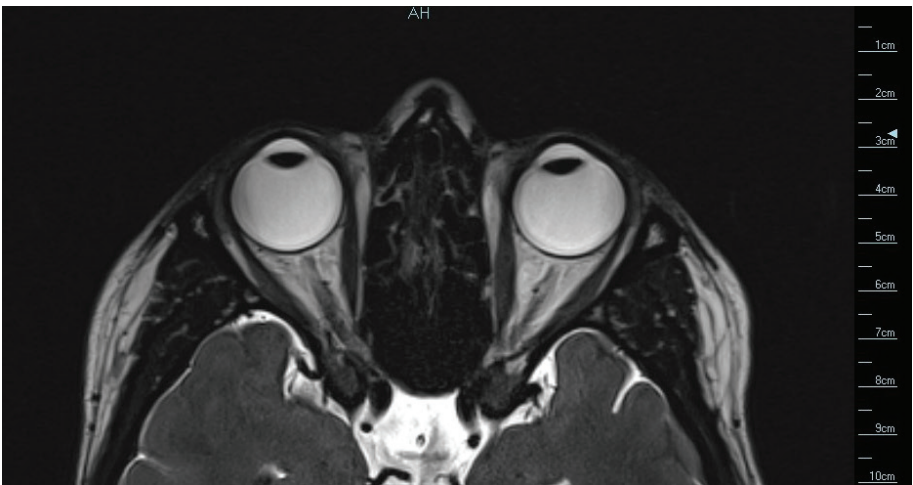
MRI of eye socket and slightly bulky extraocular muscles
